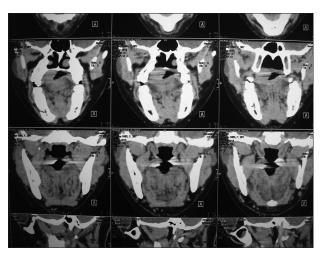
CT Scan reporting no erosion or perforation of palate
